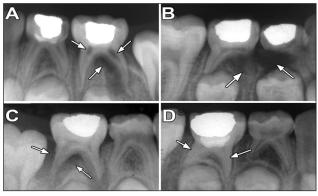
Examples of radiographic failures: (A) internal resorption and inter-radicular radiolucency (calcium hydroxide/24 months); (B) external and pathologic root resorption (calcium hydroxide/24 months); (C) external root resorption and inter-radicular radiolucency (calcium hydroxide/24 months); (D) pulp canal obliteration (ProRoot MTA/24 months).
